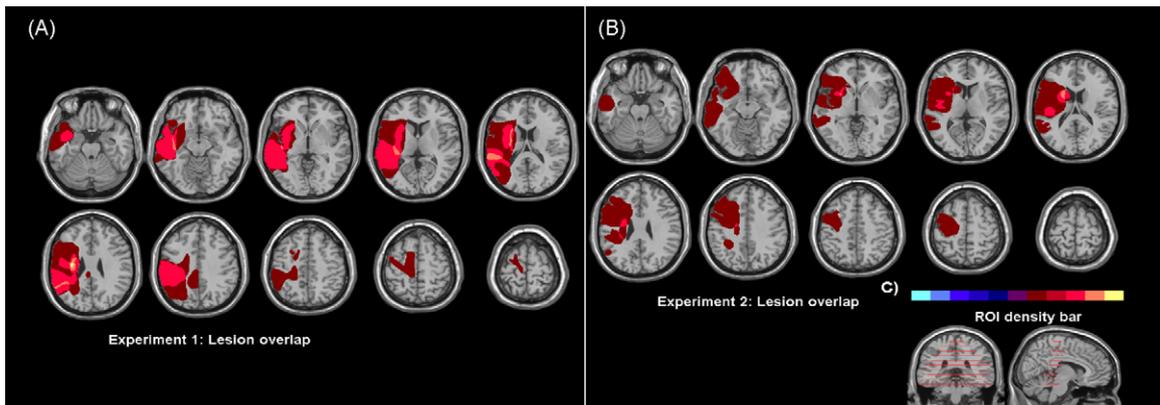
Panel A and B show MRI's and PET's images of lesion overlap for patients in experiment one and two. Panel C shows the density bar and the location of the slices.
